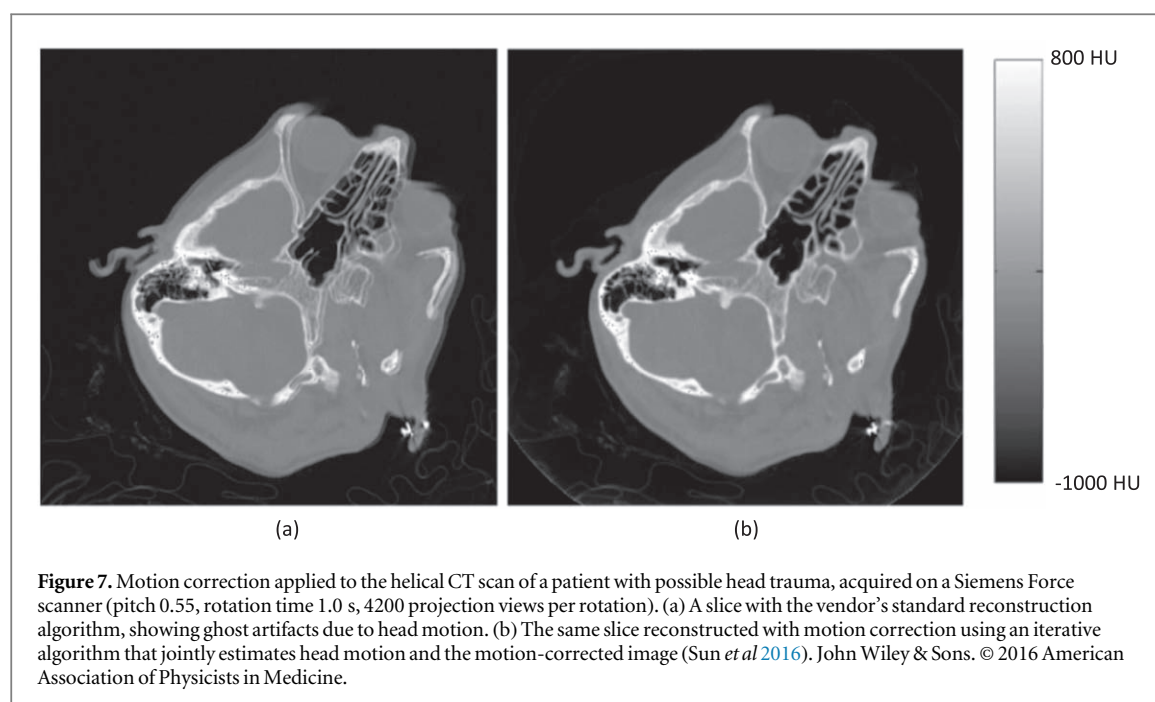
Motion correction applied to the helical CT scan of a patient with possible head trauma, acquired on a Siemens Force scanner (pitch 0.55, rotation time 1.0 s, 4200 projection views per rotation). (a) A slice with the vendor's standard reconstruction algorithm, showing ghost artifacts due to head motion. (b) The same slice reconstructed with motion correction using an iterative algorithm that jointly estimates head motion and the motion-corrected image (Sun *et al* 2016). John Wiley & Sons. © 2016 American Association of Physicists in Medicine.
